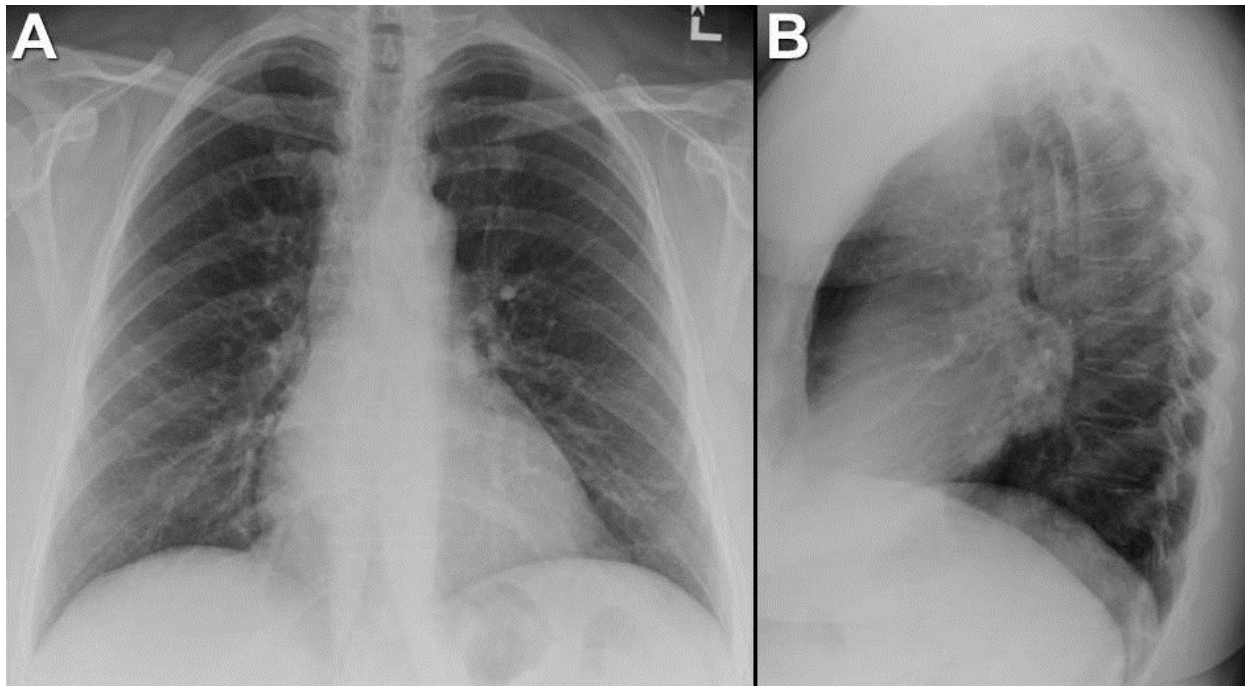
Figure 1: Frontal (A) and lateral (B) chest radiography.
